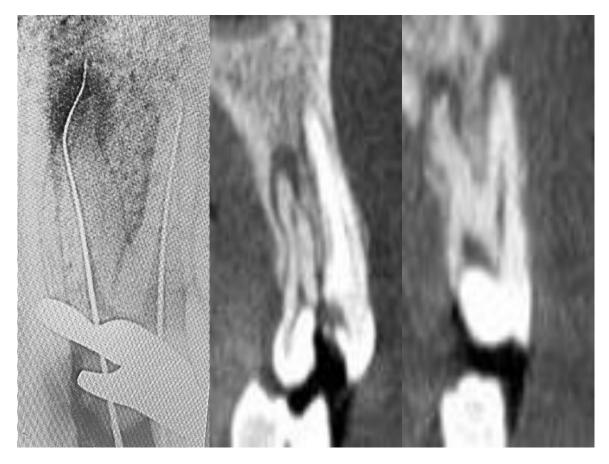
Pre-treatment, A) perforation of palatal root. B&C) CBCT showing root curvature and periapical lesion. *Rashad et al.*, 2024
